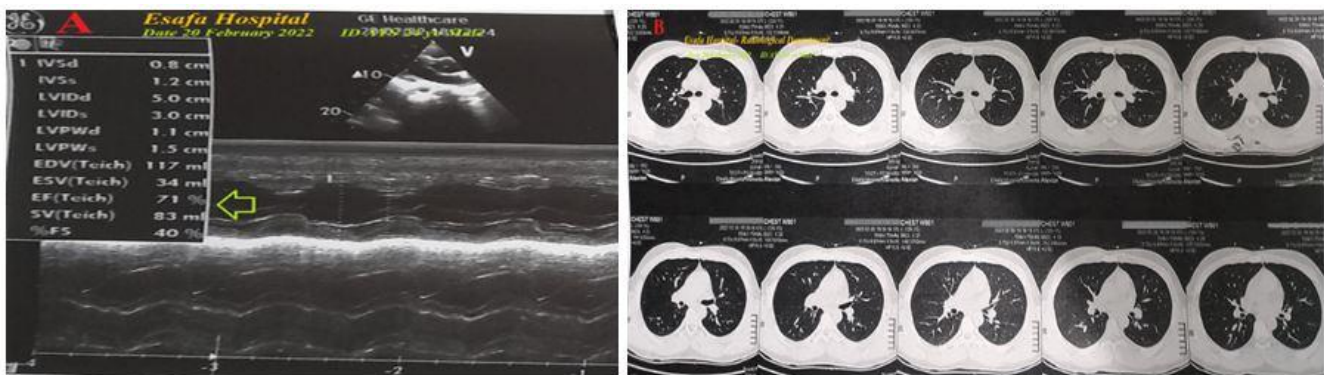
2A. Echocardiography was done on the day of the ICU admission and showed no abnormalities detected with normal EF (71%) (lime arrows). 2B. Chest CT on the day of the ICU admission showed no abnormalities detected.
